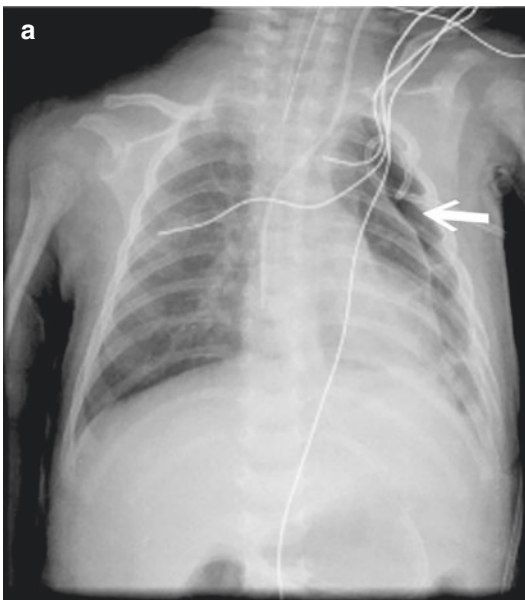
Chest radiography of case 2 showed (a) a pneumatocele (arrow) in the left upper lung on the eighteenth day of hospitalization and (b) resolution of the pneumatocele on hospital day 3
